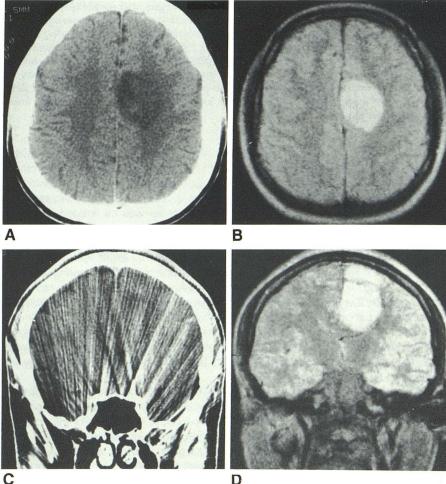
A, CT of oligodendroglioma. Poor definition of lateral border of lesion. B, MR. Borders are well defined.
